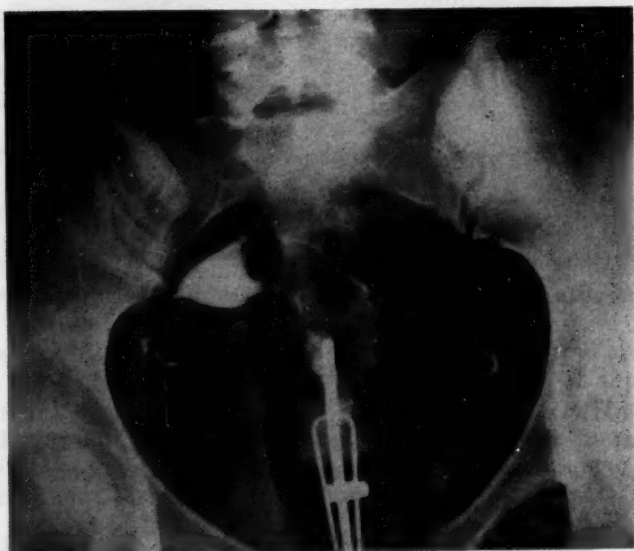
X-ray plate of the pelvis after a total of 4 c.c. of Medopaque-H has been instilled. The opaque medium can be seen at the fimbriated end.
